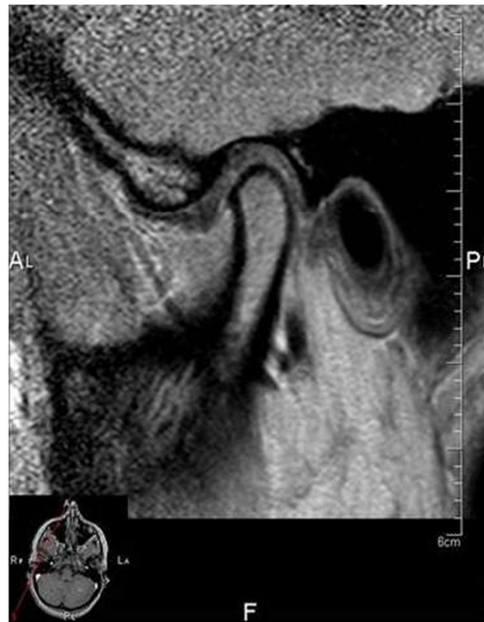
MRI of Right TMJ in Oblique Sagittal Planar Section
